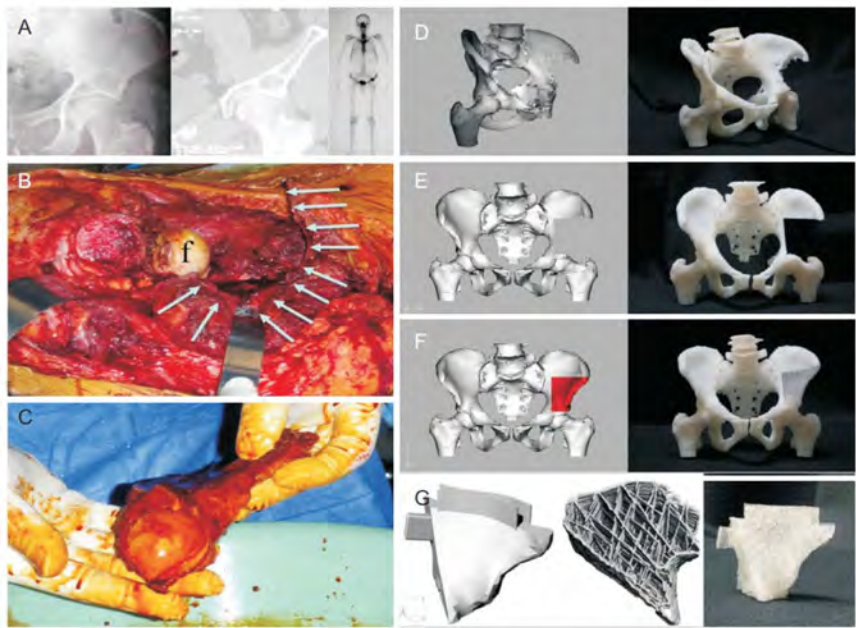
Combined use of CAD and scaffolds as clinical therapy after resection of musculo-skeletal sarcoma. Clinical case of orthopedic regenerative medicine after resection of malignant bone tumor. Custom scaffold designed from CT data of the patient pelvis and fabricated via additive manufacturing. The implant fits the macro-scale geometries of the specific application, while the porous structure facilitate osteointegration. Image taken from [94].
